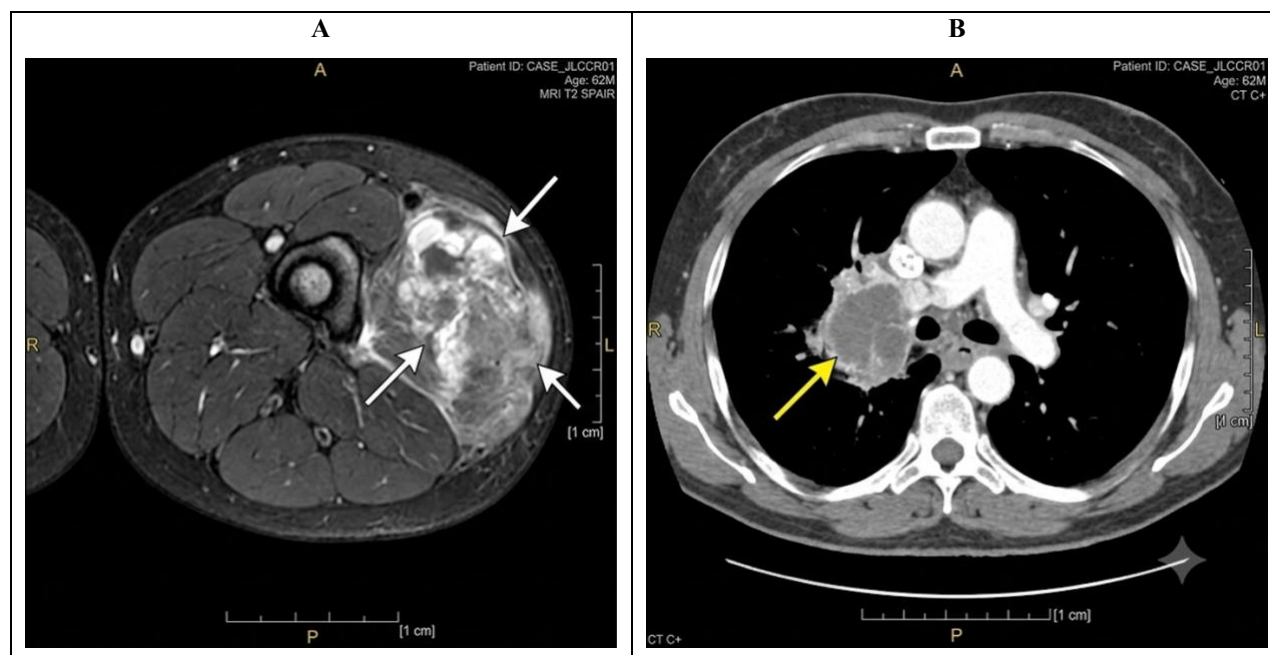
Initial Radiographic Presentation of Solitary Skeletal Muscle Metastasis. (A): Contrast-Enhanced MRI of the Left Thigh; (B): Contrast-Enhanced Thoracic Computed Tomography (CT).
